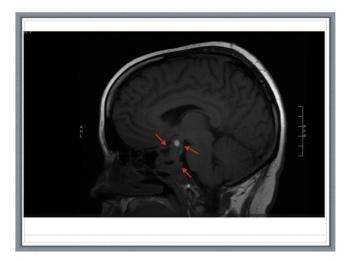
Magnetic resonance image of head. T1-weighted sagittal view, demonstrating significant decrease in tumor size.
